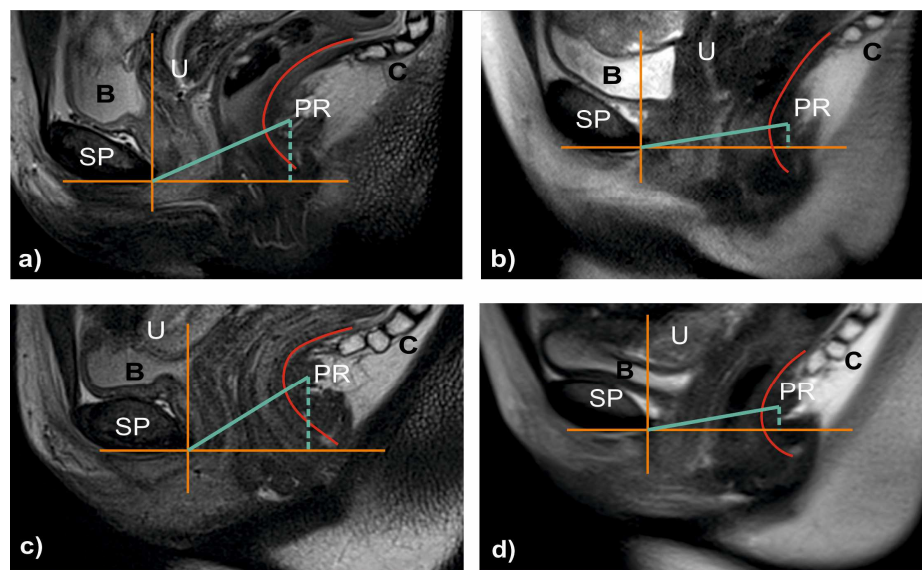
MR images in the mid-sagittal plane of a continent (a and b) and incontinent woman (c and d). Images acquired at rest position (a and c), and during maximal Valsalva manoeuvre (b and d). The antero-posterior *levator hiatus* displacement (straight blue line) and the supero-inferior displacement of the puborectal muscle (dashed blue line). B - bladder; C - coccyx; PR - puborectal muscle; SP - *symphysis pubis*; U - uterine cervix.
